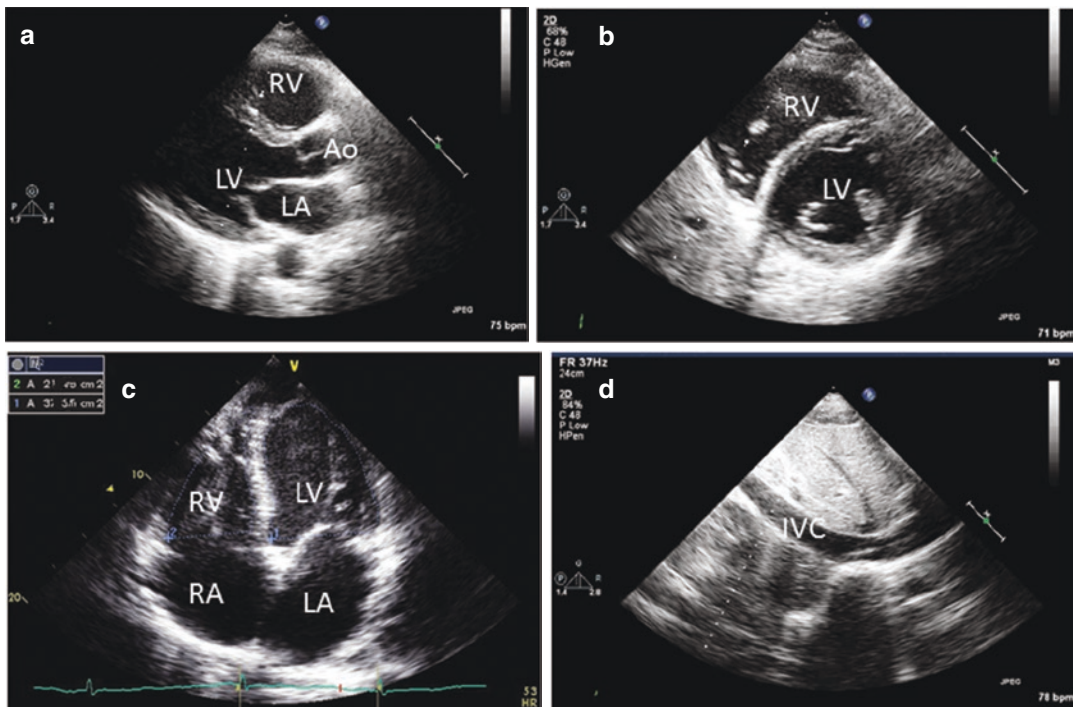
Transthoracic echocardiographic views. (a) Parasternal long axis view; (b) parasternal short axis view at the papillary muscles level; (c) apical 4-chamber view;
